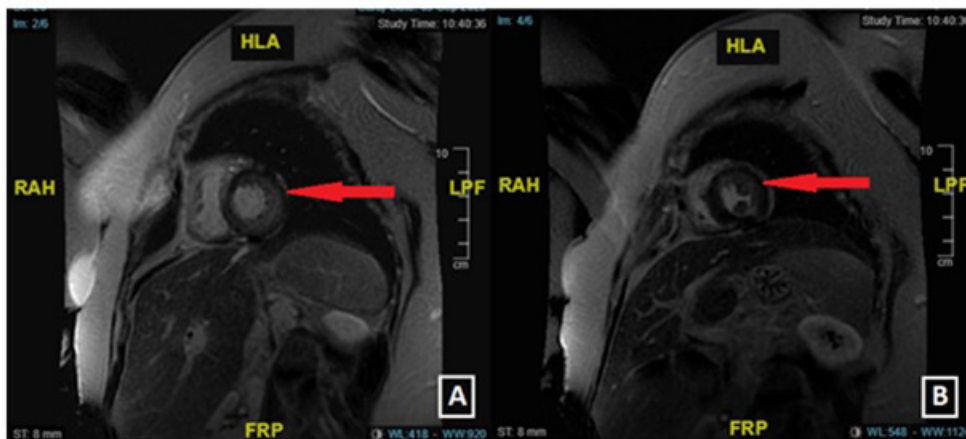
Diffuse subendocardial diffuse enhancement images, prominent in the left ventricular anterior lateral and inferolateral walls on cardiac MRI (A, B)
